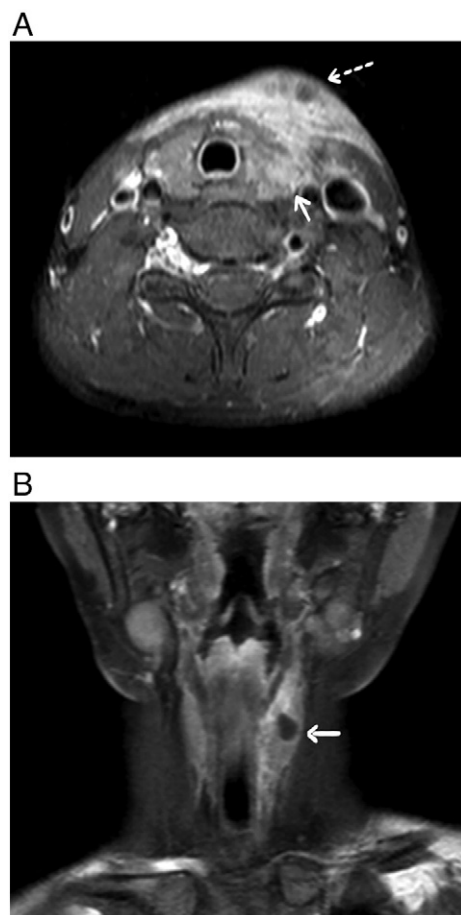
A, Cervical enhanced MRI (axial): Abnormal mass in the left anterior subcutaneous soft tissue involved left thyroid gland, which was unevenly enhanced (solid arrow). An abscess was present (dashed arrow). B, Cervical enhanced MRI (coronal): the abnormal mass of the left side neck involved the left thyroid and showed uneven enhancement. A traveling air-filled fistula was observed (arrow).
